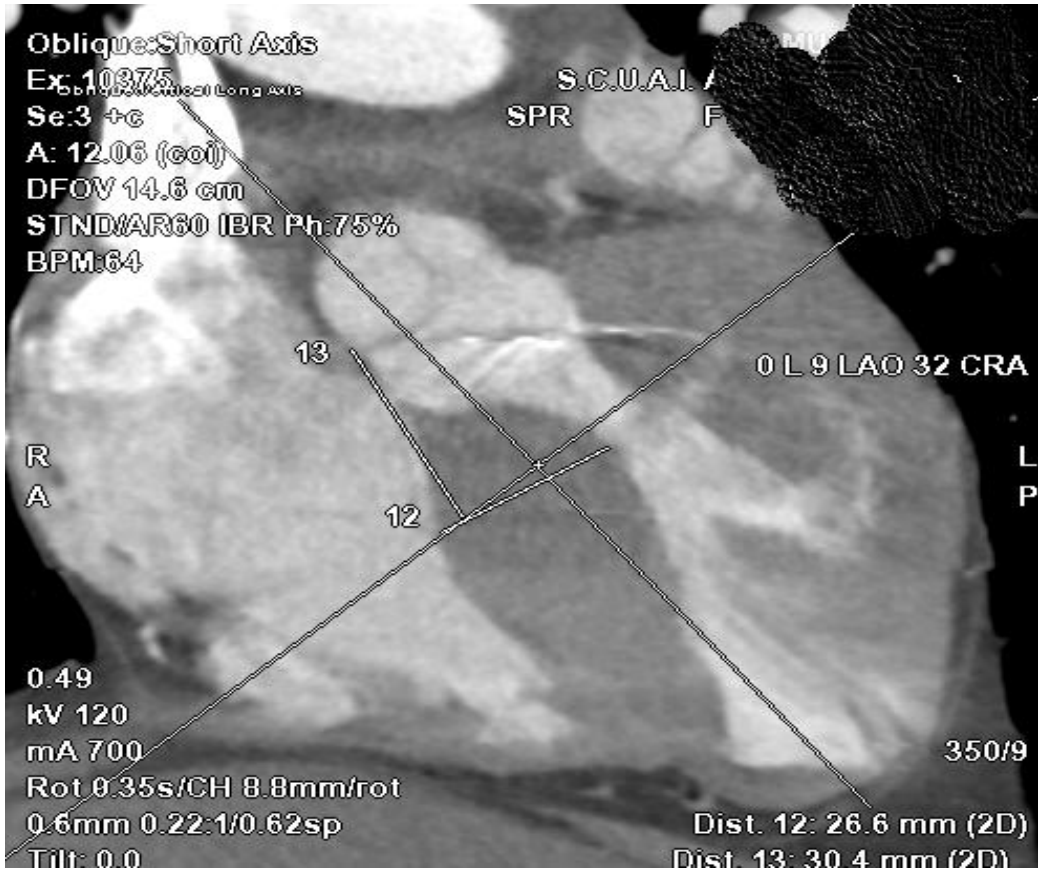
Cardiac CT showing severe septal hypertrophy, narrowed LVOT and small LV cavity
